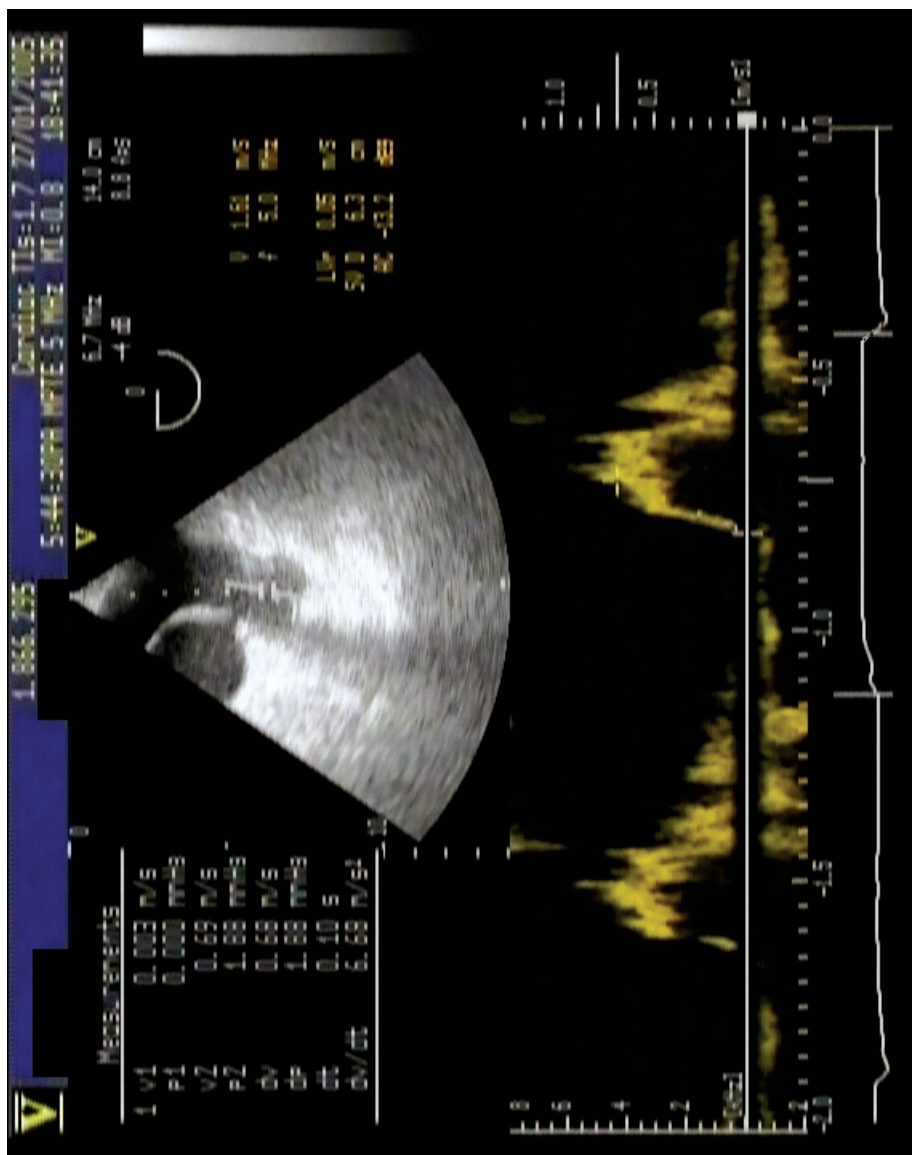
Example of mean acceleration measurement of the pulmonary artery on high-speed Doppler recording. The bottom line represents airway pressure. The measured beat on the right is during inspiration.
